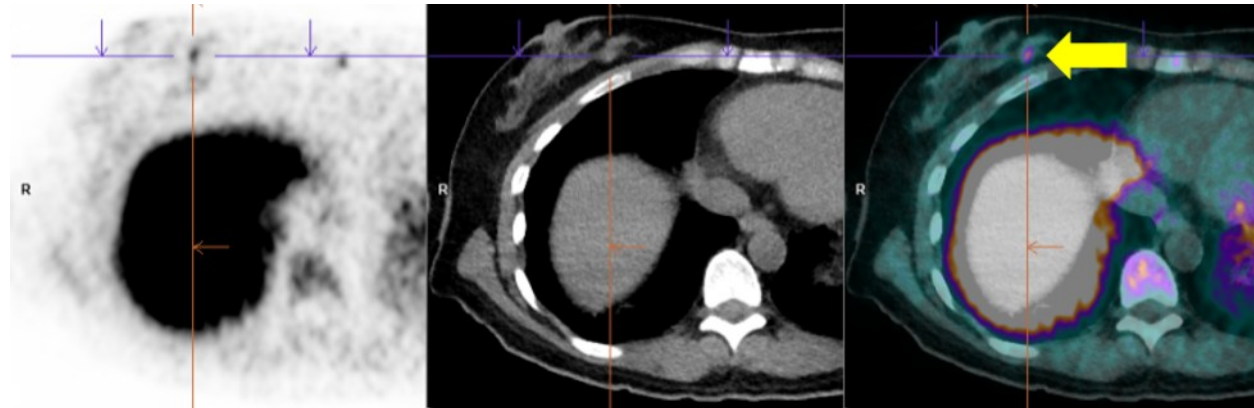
Axial PET/CT images of the chest show an incidental finding of a small mildly FCH-avid focus in the lower inner quadrant of the right breast, with SUV of 3.7 (yellow arrow).
